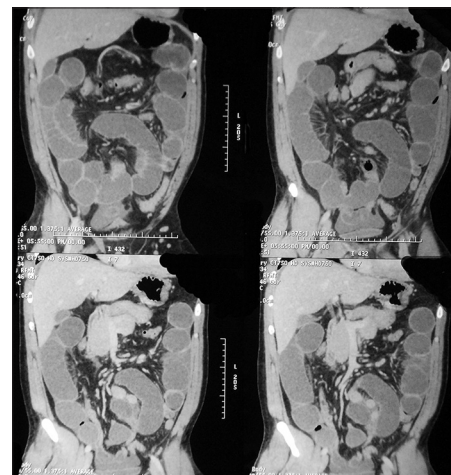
Coronal computed tomography of abdomen. Note the dilated fluid-filled small bowel loops suggesting acute intestinal obstruction. Meckel's diverticulum could not be identified
